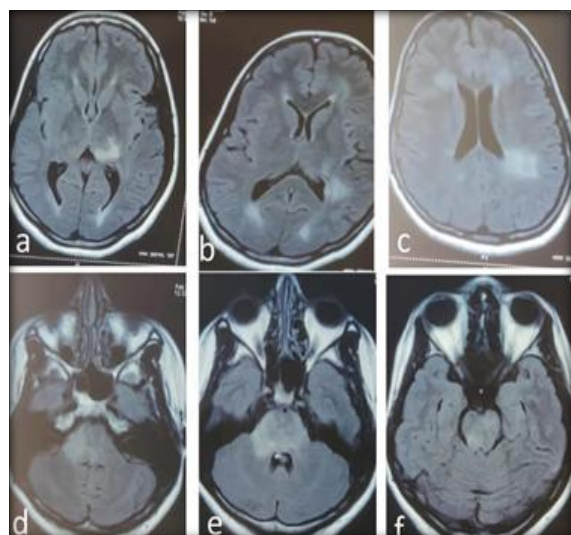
MRI Brain T2FLAIR images showing hyperintense signal in left thalamus (a), bilateral subcortical occipital regions (b), bifrontal region (c), right middle cerebellar peduncle & bilateral pons (d, e), midbrain (f) seen in MOGAD cases
